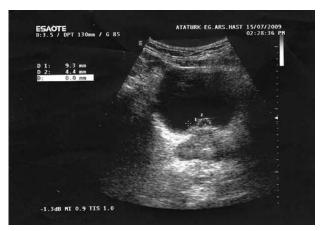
Appearance of the prostatic cyst on abdominal ultrasonography.
